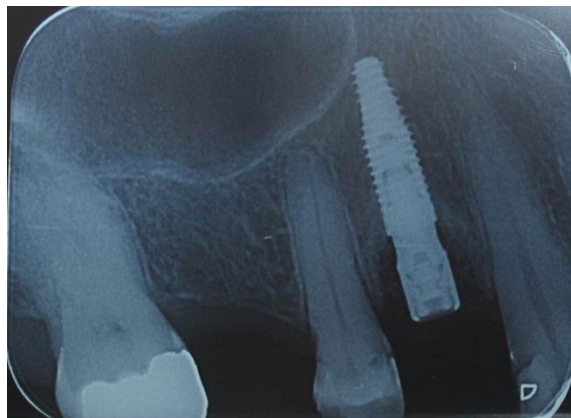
Radiografia periapical pós-operatória. Fonte: a autora.
